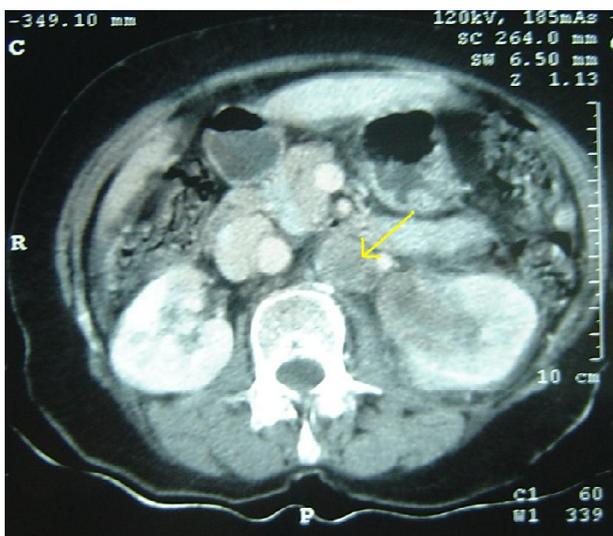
CT scan showing a tumour in the left renal pelvis. The yellow arrow head shows the lymph node.
